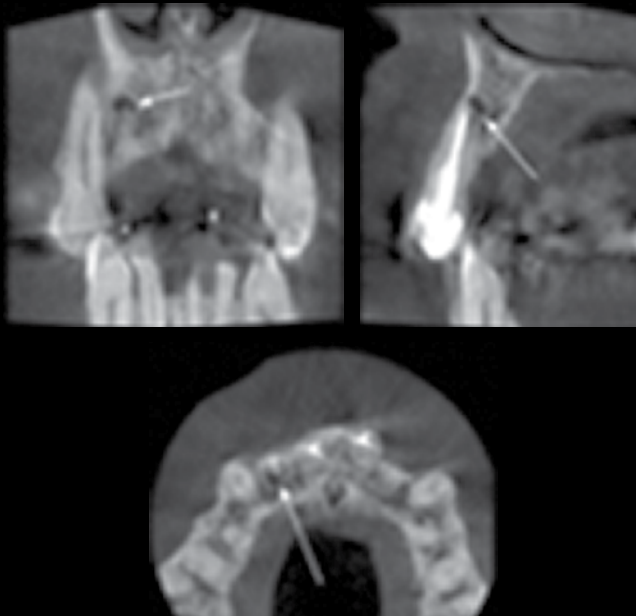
A small-volume cone beam computed tomography scan confirming a periapical lesion on the UR2. There was no radiolucency around the apex of the UR1.
